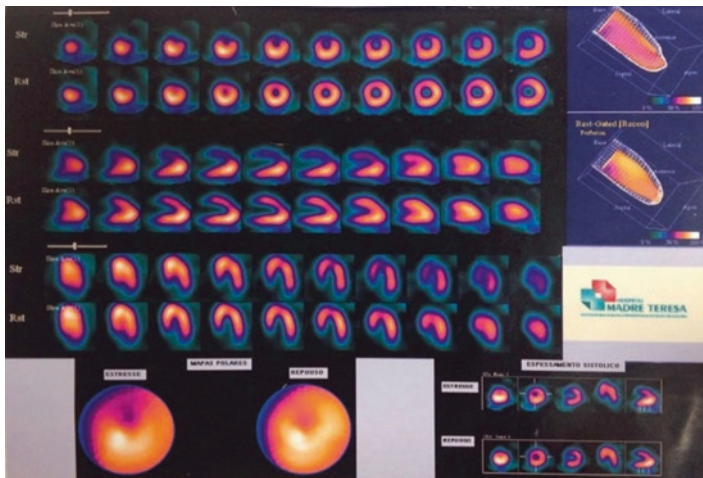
Myocardial scintigraphy stress test showing transient myocardial ischemia in the anterior wall of the left ventricle with moderate length and marked degree
